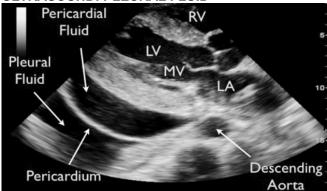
PARASTERNAL VIEW OF PLEURAL FLUID. The pleural effusion is posterior to the descending aorta.
